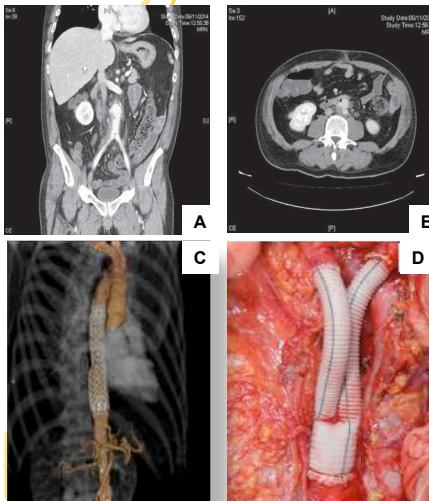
Figure (A) Angio-CT with deflected image of saccular morphology, with irregular contours, that coexist with a mass of non-peritoneal, non-capturing parts. (B) Angio-CT (transverse section) where a peritoneal gas bubble is seen and an enterogastrostic fistula. (C) Three-dimensional reconstruction after endovascular repair of a ruptured mycotic aneurysm in the descending thoracic aorta. (D) Anatomical reconstruction using rifampicin-soaked Dacron graft.
